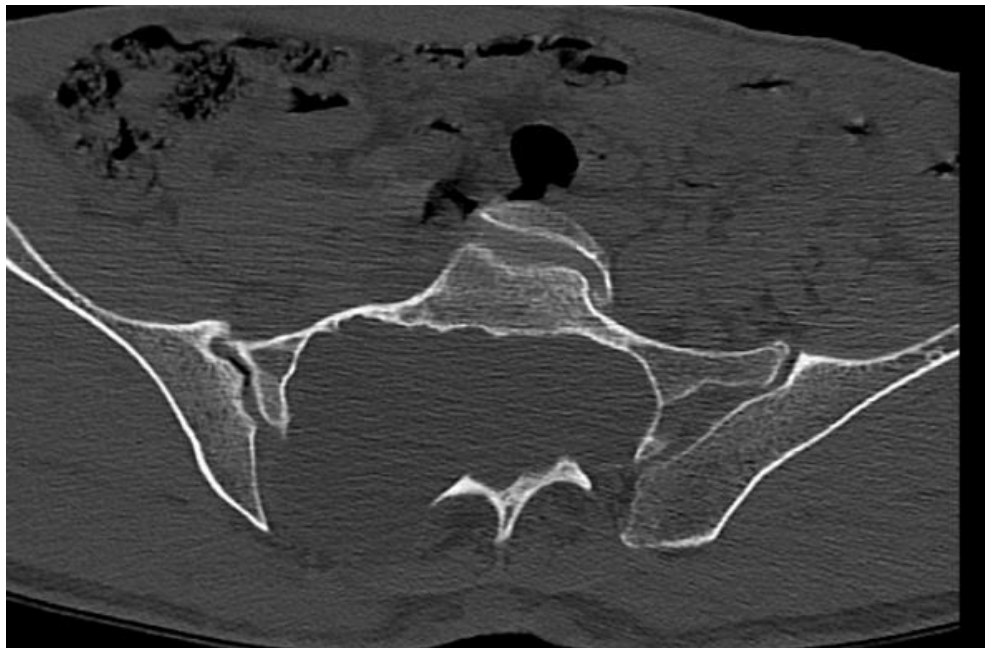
Axial CT images of the lumbosacral spine demonstrating vertebral dysplasia with posterior scalloping and associated anterior and posterior sacral meningoceles, with widening of the neural foramina.
